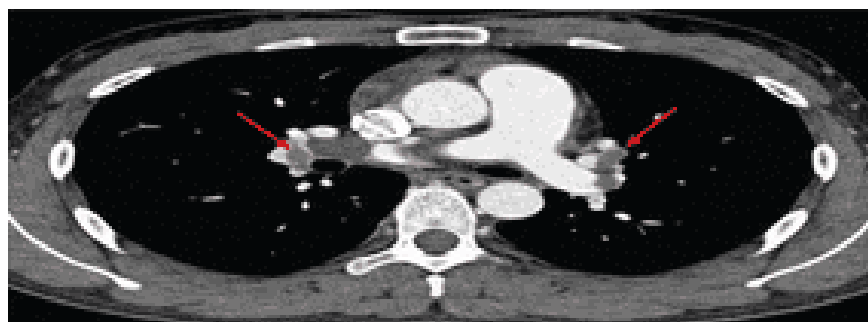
Computed tomography pulmonary angiography showing large filling defects in both right and left main pulmonary arteries (arrows) extending into the lobar and segmental branches, consistent with massive bilateral pulmonary embolism
